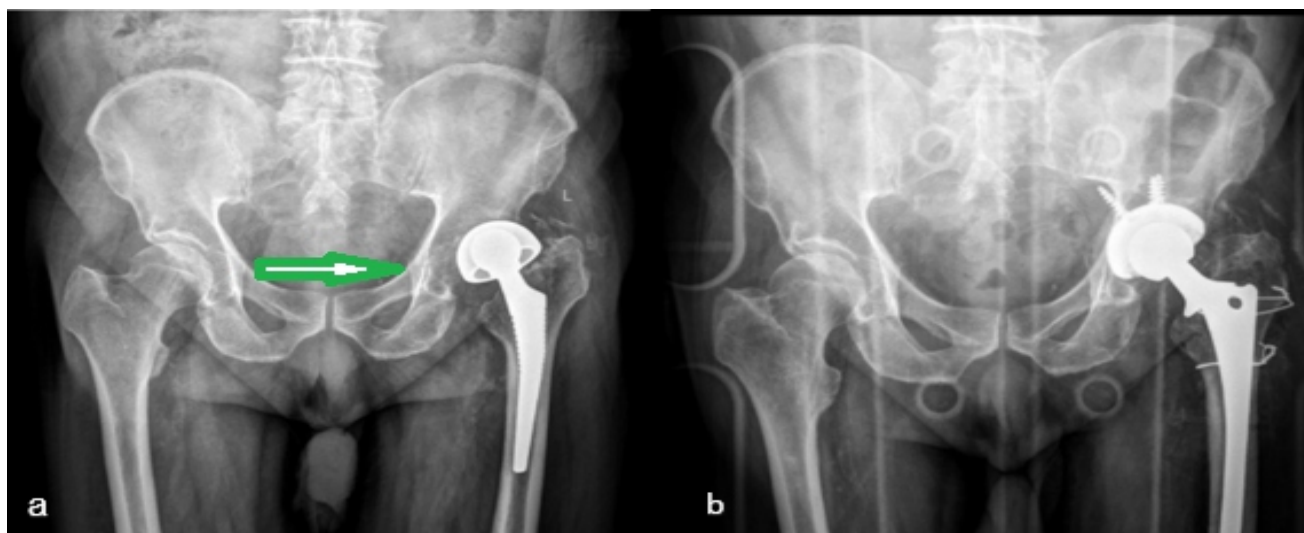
(a) Case 1 prosthetic infection with a subluxed hip, (b) 2.5-year follow-up radiograph after revision total hip arthroplasty
